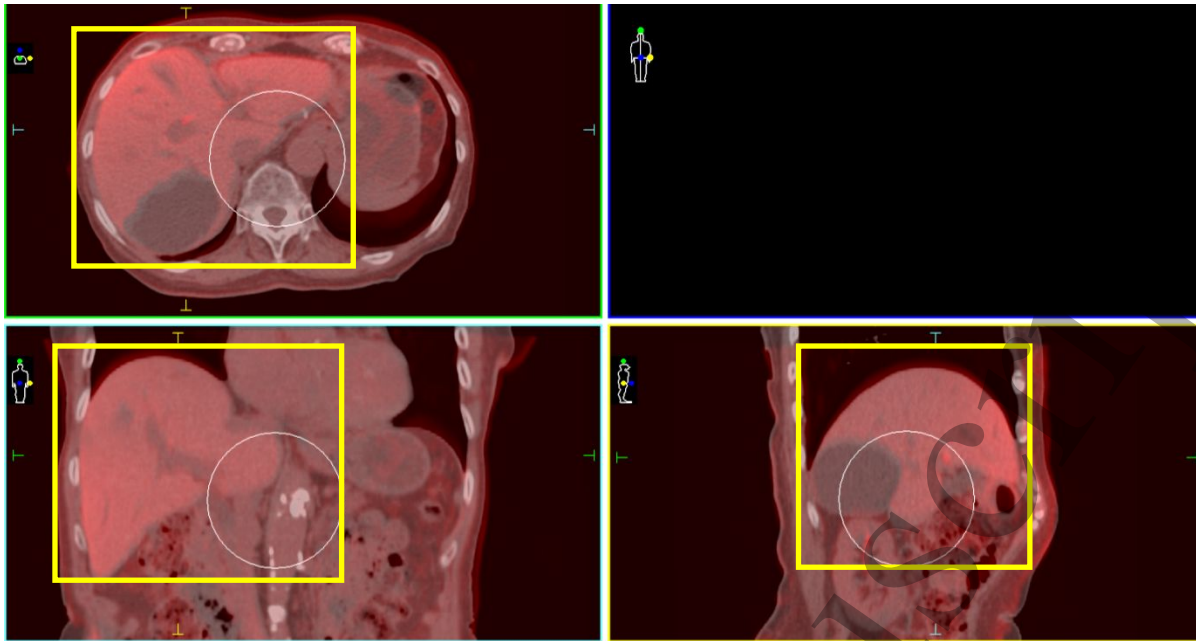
Local RIR for a patient with a liver metastasis. Grey overlay images are CT and red overlay images are MRI. The recommended guiding ROI for the local registration covers the whole liver and is shown in yellow.
